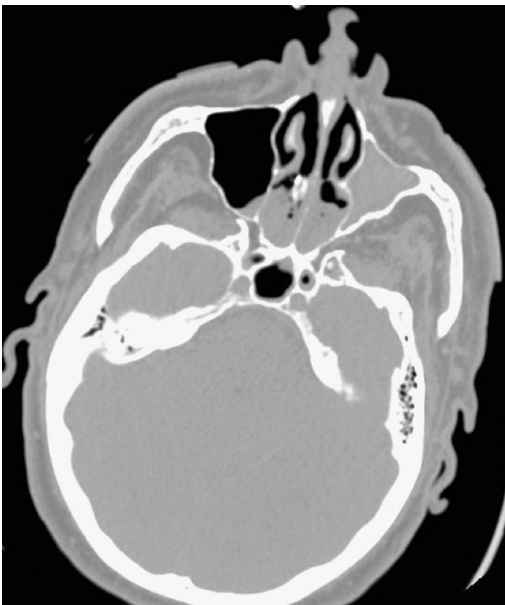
Computed tomography images of sinus, axial view, opacification of left maxillary sinus.
